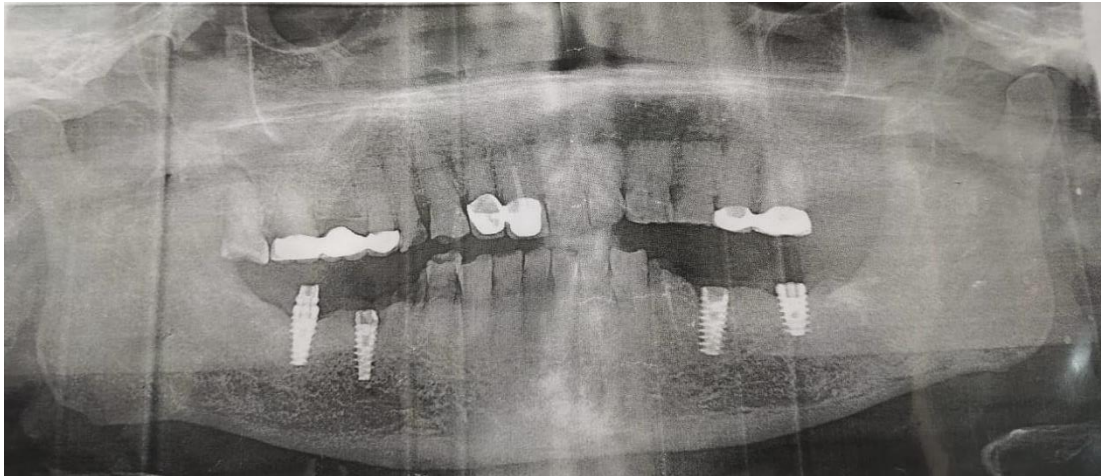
Preoperative Radiograph with fractured abutment screw
